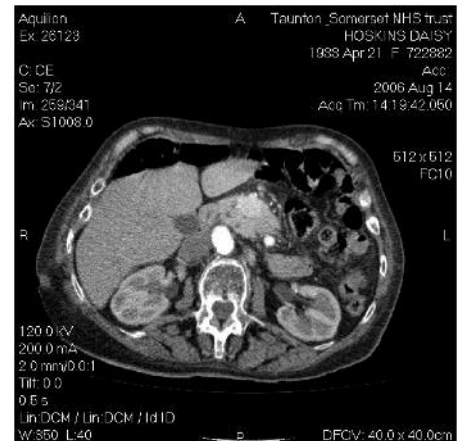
CT abdomen showing the lesion in the head of pancreas.
